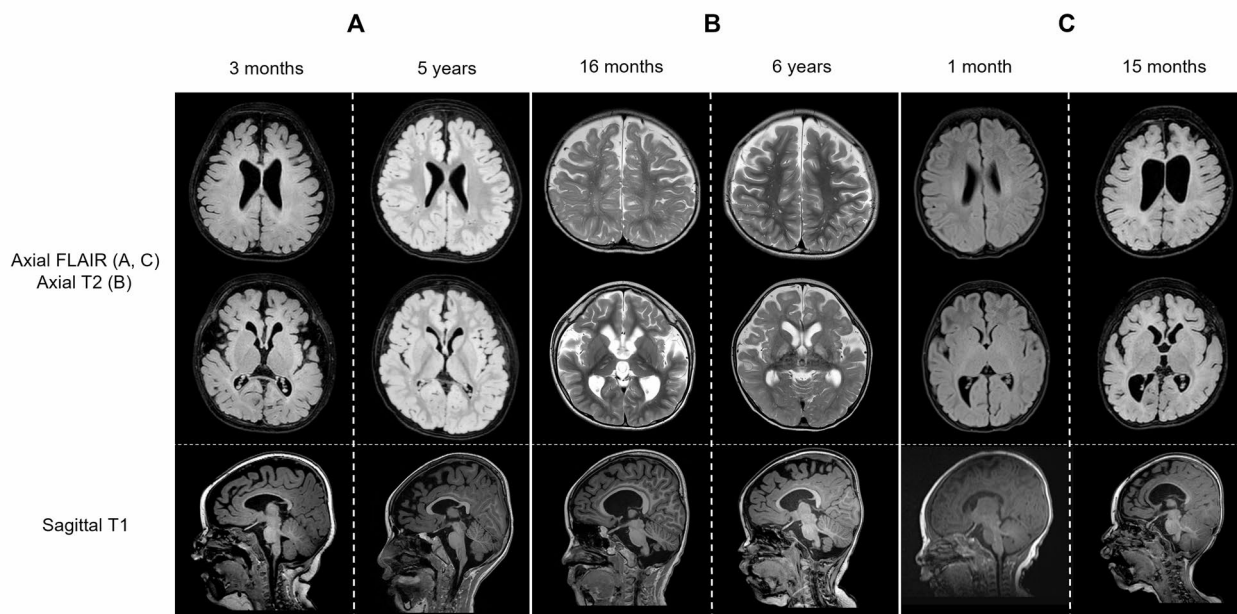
Brain MRI findings of Patients 1, 2, and 3. (A–C) Serial brain MRI images of Patients 1, 2, and 3. The first and second rows show axial FLAIR images for (A and C) and axial T2 images for (B). The last row shows sagittal T1 images. (A) MRI image of Patient 1 taken at 3 months (left) and 5 years (right). The axial images show prominent perivascular spaces and high signal intensity in the thalamus. The sagittal images reveal dysmorphic corpus callosum. (B) MRI image of Patient 2 taken at 16 months (left) and 6 years (right). The axial images show prominent perivascular spaces with T2 hyperintensity in the bilateral basal ganglia and the thalamus. (C) MRI image of Patient 3 taken at 1 month (left) and 15 months (right). MRI performed at 15 months shows diffuse cerebral atrophy with a thin corpus callosum.
